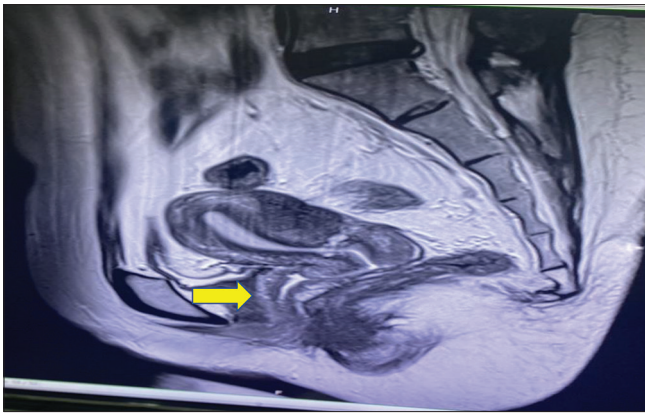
T2-weighted image of the cervix
